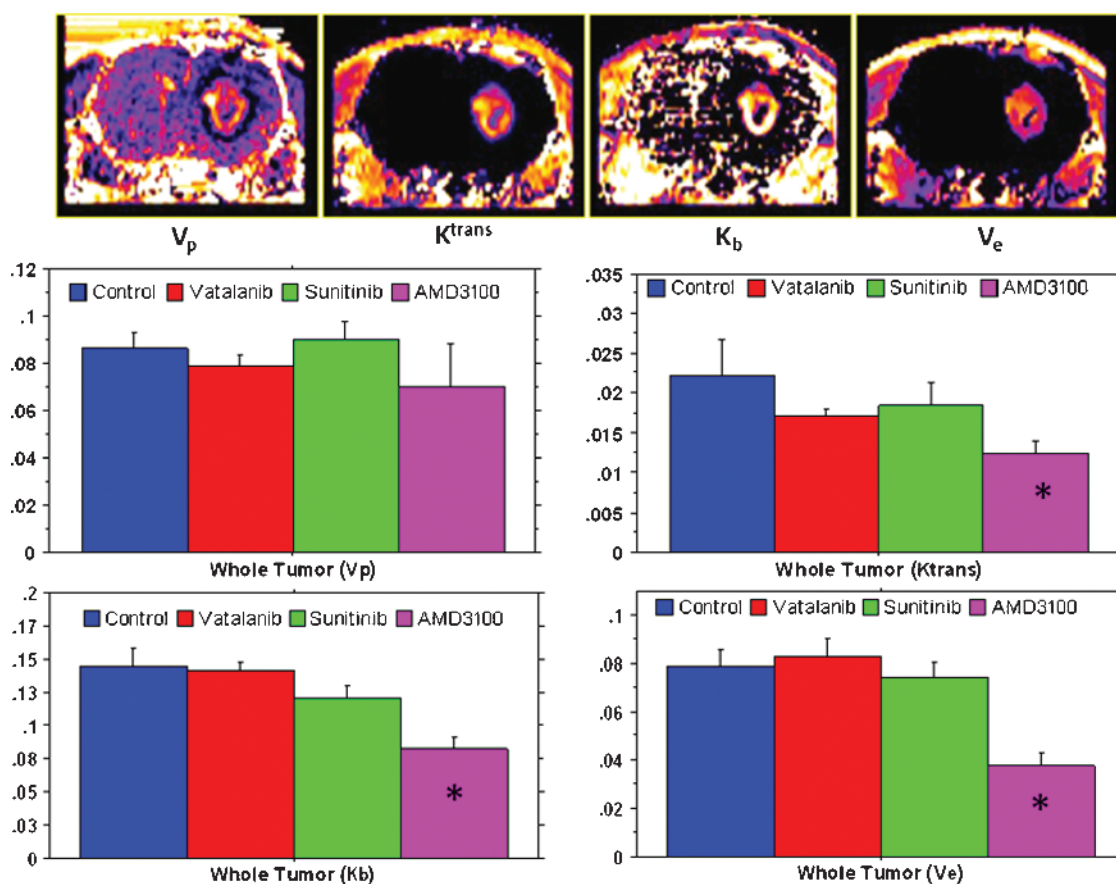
MRI vascular parametric analysis after antiangiogenic therapy. The upper panel shows maps from a representative case showing tumor plasma volume (V_p), vascular forward transfer constant (K^{trans}), backflow transfer constant (K_b), and interstitial space volume (V_e). The middle and lower panels show quantitative estimations of V_p , K^{trans} , K_b , and V_e after the drug treatment. Note the significant decreased K^{trans} , K_b , and V_e in tumors treated with AMD3100. * $P < .05$. All tumors were in the right hemisphere.
